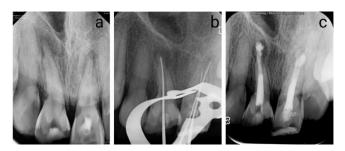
a: Radiograph taken two months after the second recall, showing significant healing in tooth 21 and cessation of the resorption process in tooth #11. b: Radiograph confirming the working. c: Radiograph displaying the final obturation in teeth #11 and #21 after MTA application and warm vertical technique with gutta-percha.
